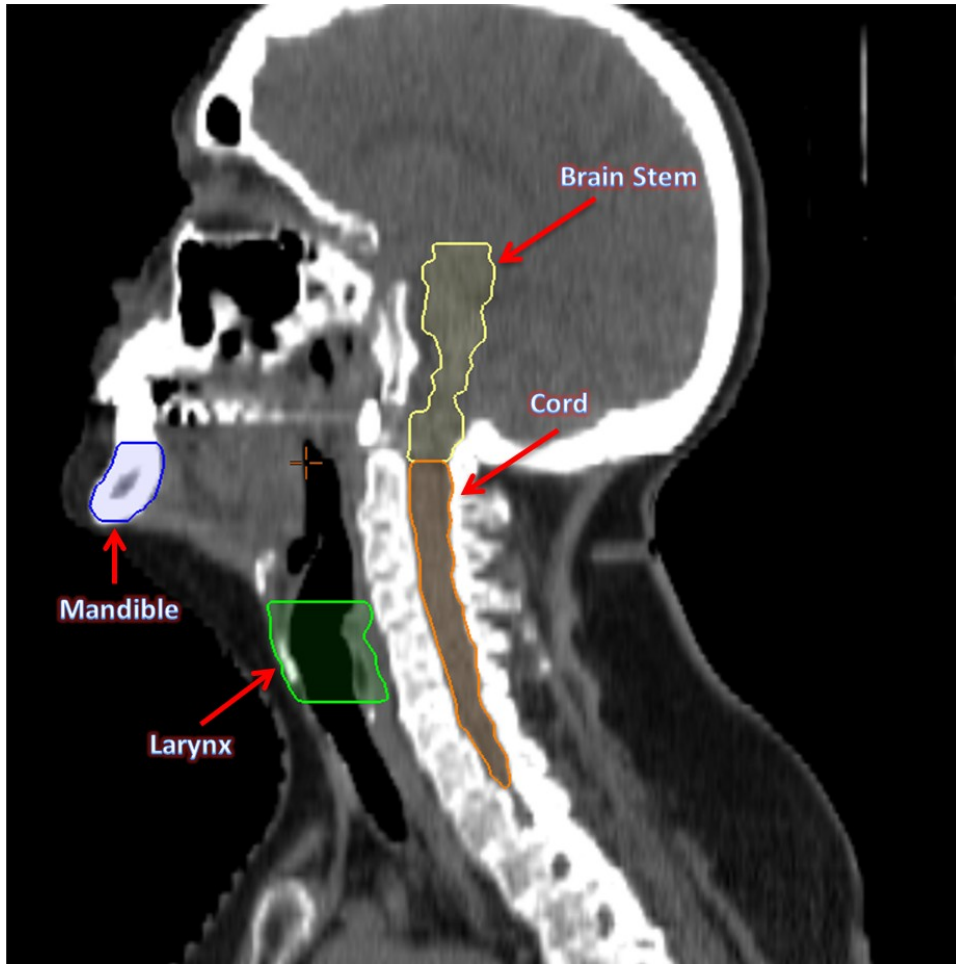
d: Sagittal view of the original head & neck CT image with the associated RT structures brain stem, cord, larynx and mandible.
